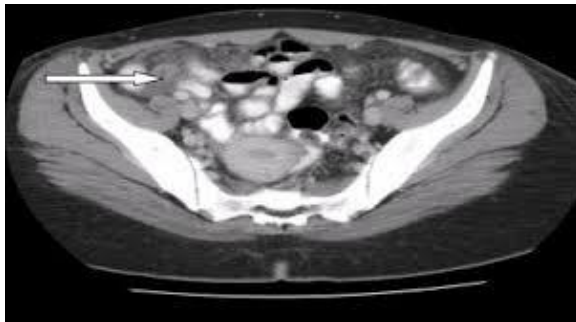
CT scan show appendicular mass      Figure (2) US show Appendicular mass
